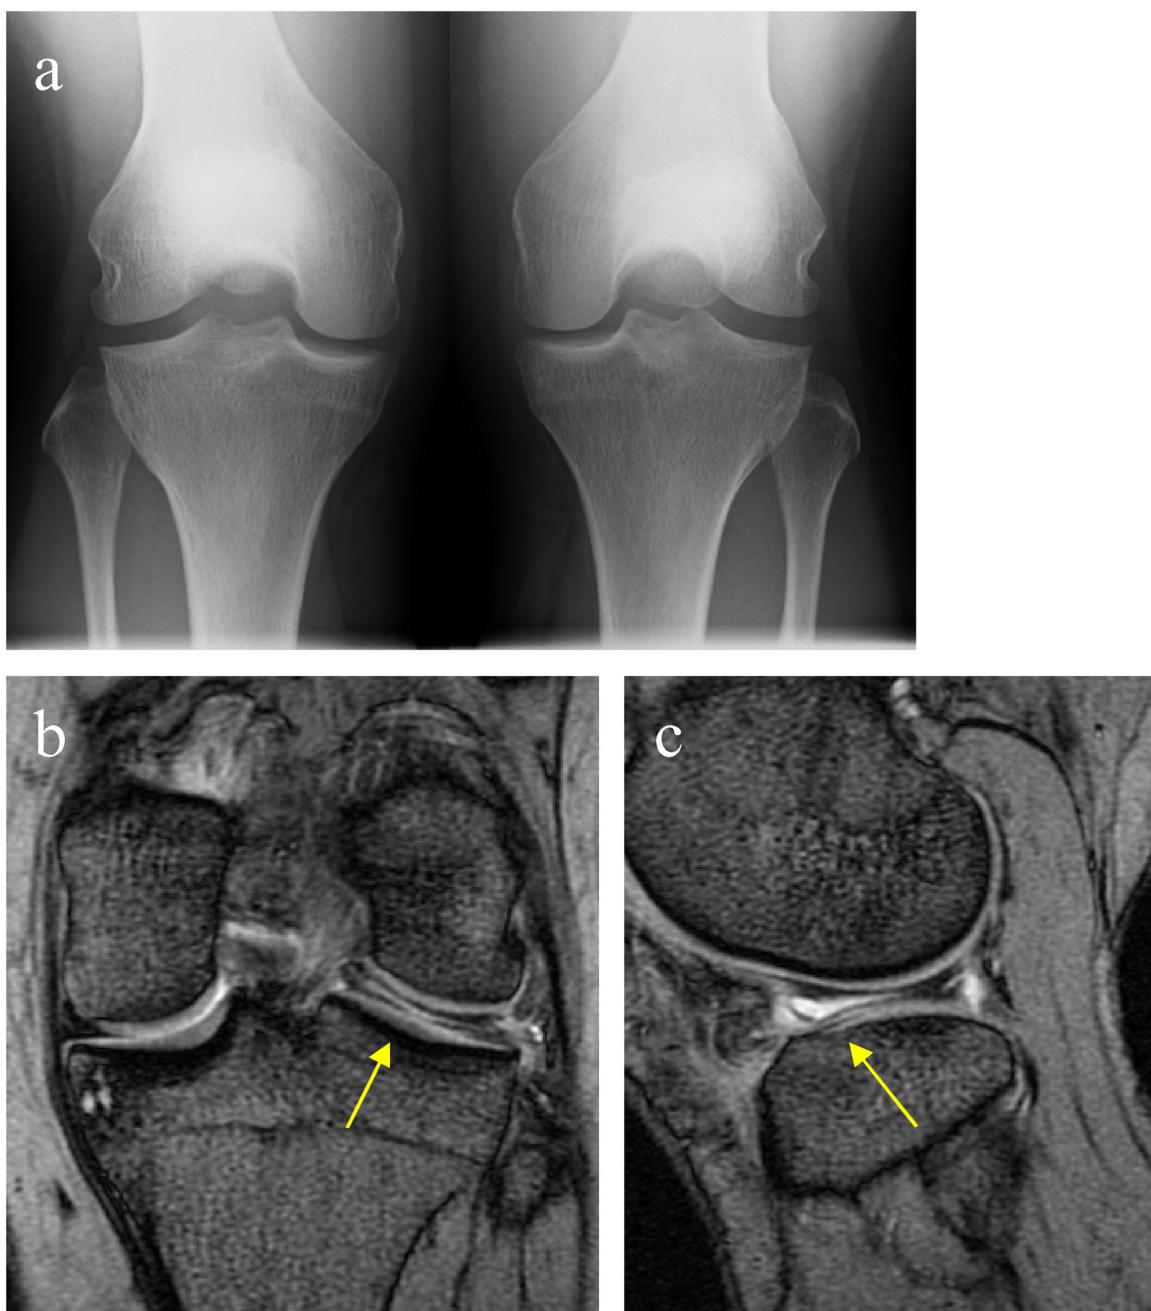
Preoperative images of the first case. Rosenberg-view radiograph of bilateral knees (a). T2-weighted MRI shows a discoid lateral meniscus with a horizontal high signal cleavage (arrow) throughout its body in mid-coronal (b) and mid-sagittal (c) sections.
